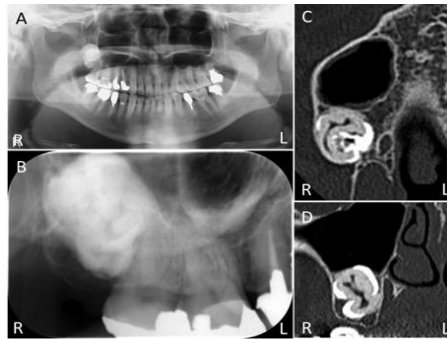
Radiography and computed tomography (A) Panoramic, (B) Dental radiography showing a radiopaque mass is located in the right maxilla, (C) Transverse plane of computed tomography images. The radiopaque mass is located in the right maxillary sinus. Some cavities can be seen in the mass, and (D) Coronal plane of CT images reveals that the radiopaque mass has pulp-like cavity
